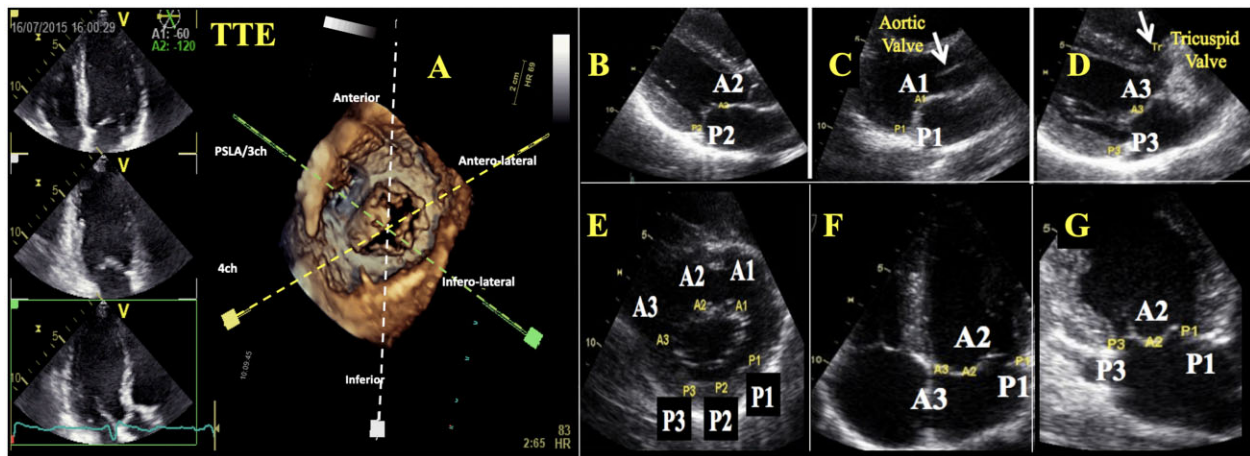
Mitral valvular segmentation analysis with 2D TTE. (A) 3D TTE cut planes across the mitral valve. (B) 2D TTE parasternal long-axis view depicting A2 and P2; (C) A1 and P1 (tilting of the probe towards the aortic valve); (D) A3 and P3 [tilting of the probe towards the tricuspid (Tr) valve]; (E) 2D TTE parasternal short-axis view depicting each scallop; (F) four-chamber view depicting A3, A2, and P1; (G) bicommissural view.
